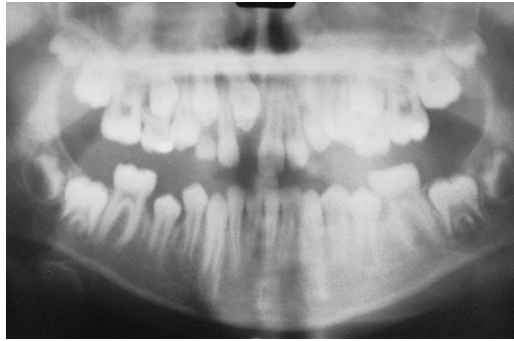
Pretreatment OPG radiograph.
